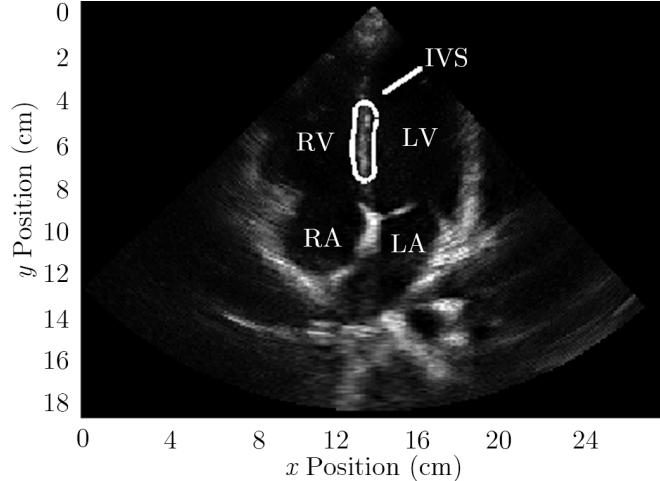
B-mode frame obtained from the apical four-chamber view of heart, with solved contour shown around the IVS. The four chambers: right ventricle (RV), right atrium (RA), left ventricle (LV), and left atrium (LA) are shown.
